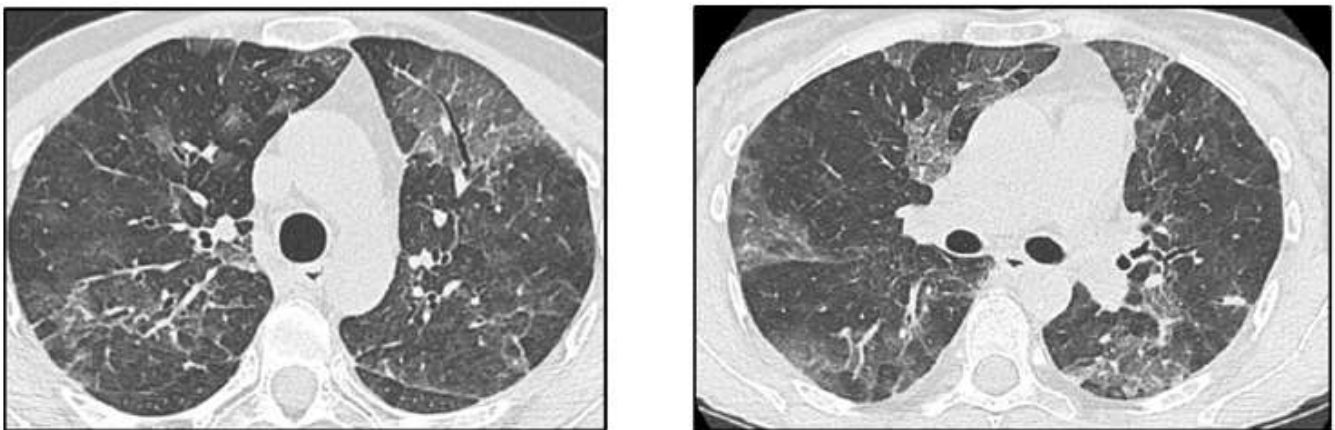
CT-scan performed after oral steroid plus azathioprine administration
